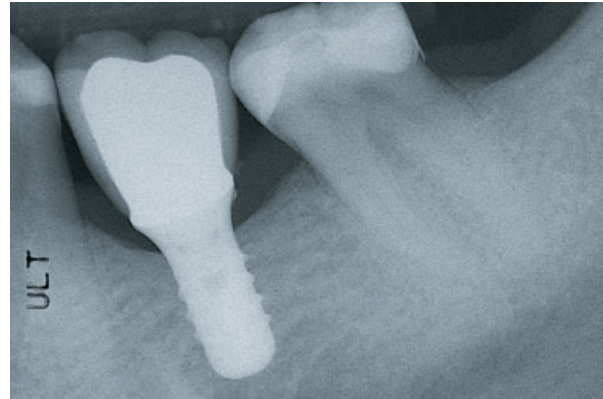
A short diameter-increased screw implant supporting a long molar-sized suprastructure is displayed on the 1-year follow-up radiograph. Note that a normal level of the first bone-to-implant contact has been maintained.
